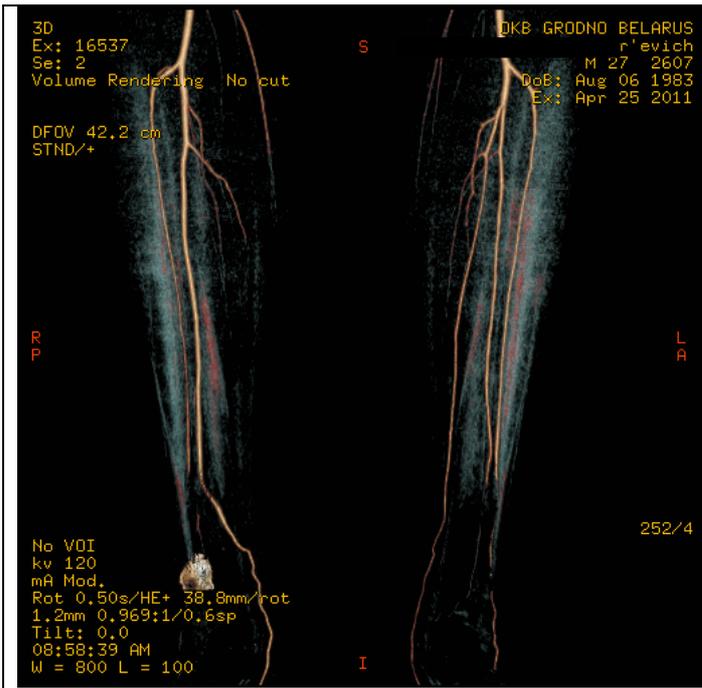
3 D spiral CT. Occlusion of the right fibularis artery.
